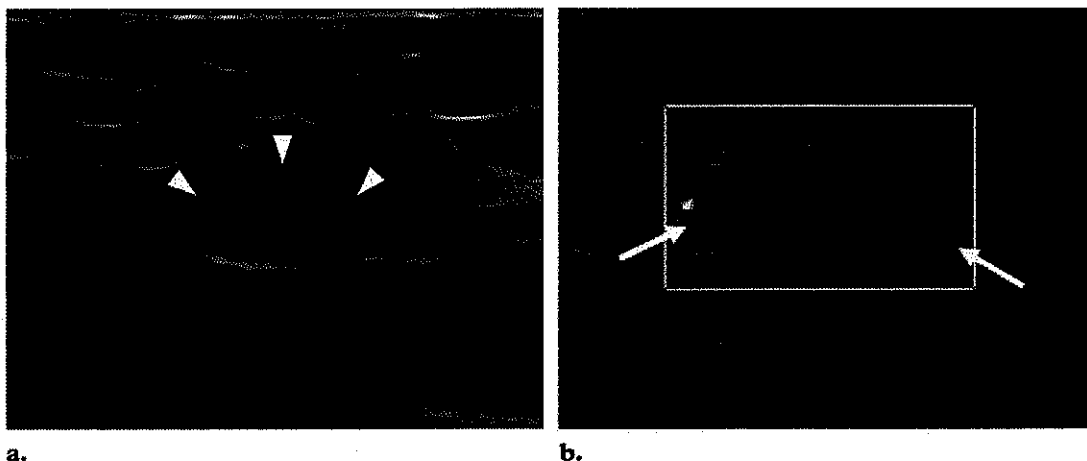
(a) US image shows an abnormal lymph node with a hypoechoic thickened cortex (arrow-heads) but no fatty hilum. (b) Color Doppler US image shows only abnormal (nonhilar cortical) blood flow (arrows); no normal hilar blood flow is seen.
